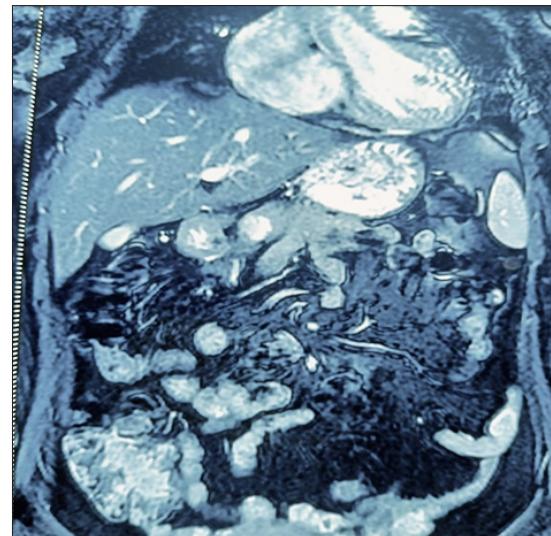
MRI – Heterogenous intra-pancreatic lesion showing arterial enhancement with a small eccentric necrotic component.
